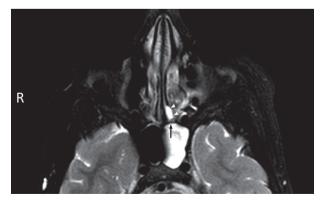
MRI coronal T2-weighed sequence showing the left cavernous sinus in close proximity of the infectious focus, between the infected sphenoid sinus medially (arrowheads) and the medial aspect of the left temporal lobe (arrows).
